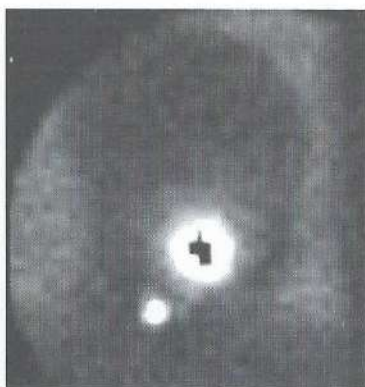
Lymphoscintigraphy reveals transport of the tracer from the injection site (large spot) along a faint lymphatic channel towards one sentinel node (small spot) in level II at early dynamic lateral imaging in a patient with a T2N0 tongue carcinoma located on the right side.
